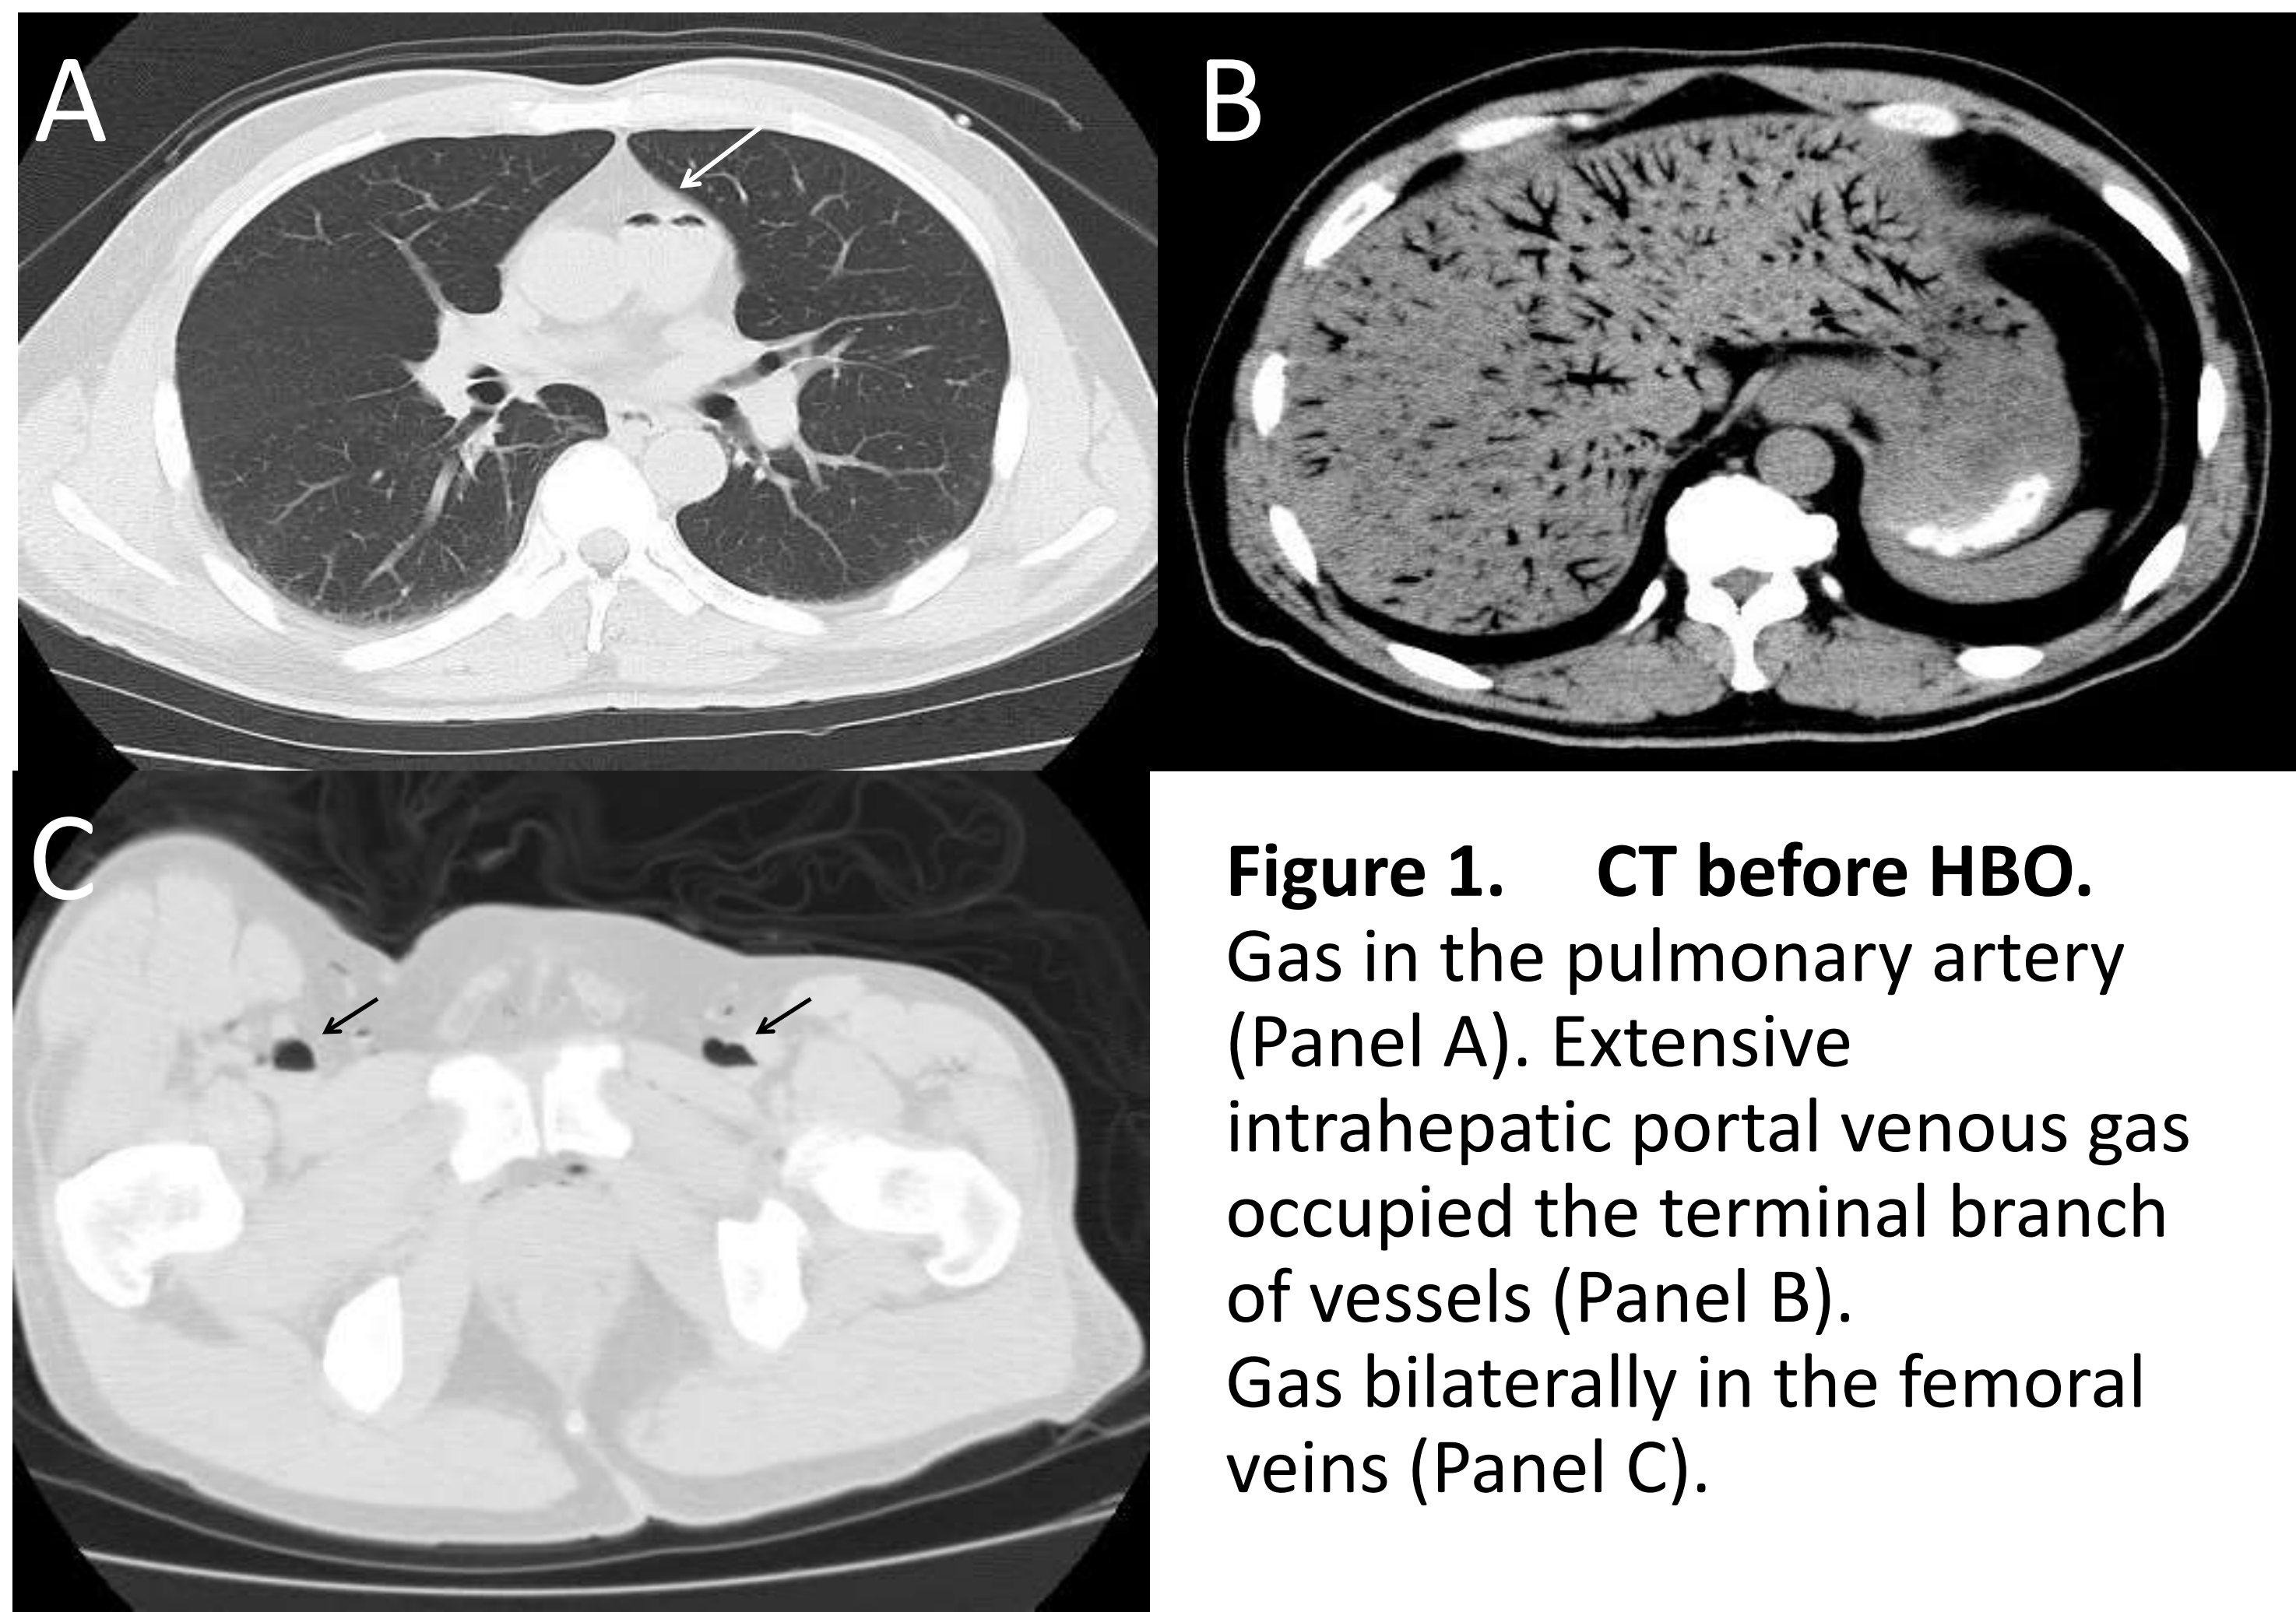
CT before HBO. Gas in the pulmonary artery (Panel A). Extensive intrahepatic portal venous gas occupied the terminal branch of vessels (Panel B). Gas bilaterally in the femoral veins (Panel C).
